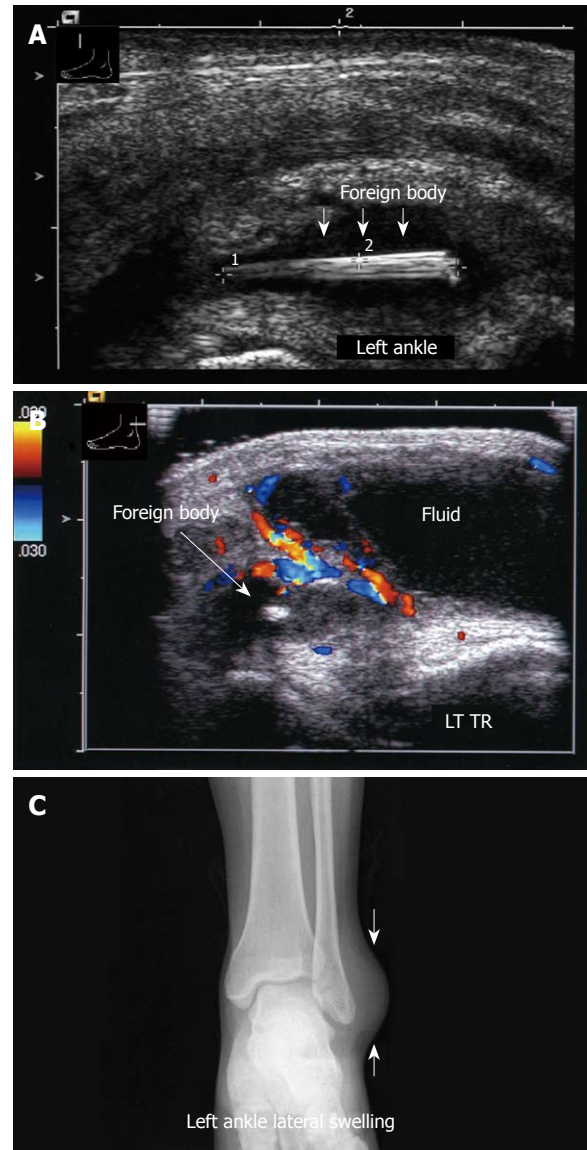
Ankle joint X-ray and US images. A: Longitudinal sonogram, left ankle, demonstrates a wooden foreign body; B: Transverse view, left ankle. Note the hypervascularity in the inflamed area; C: Corresponding X-ray of left ankle. Note the swelling on the lateral aspect. No foreign body is visible.
